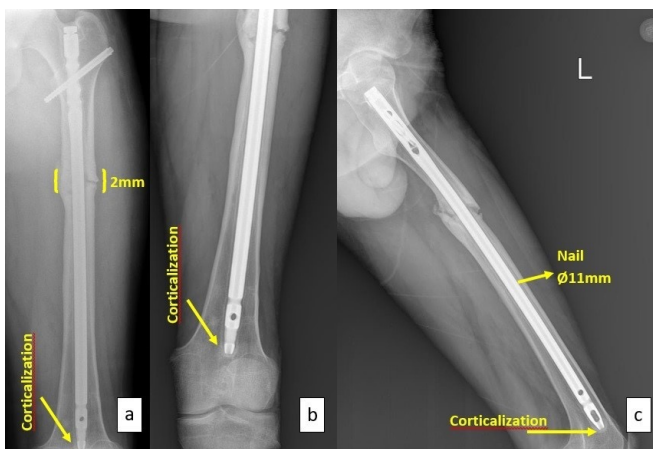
a,b-preoperative A/P radiograph showing corticalization and gap distance; b-preoperative thick corticalization image on lateral radiograph.
